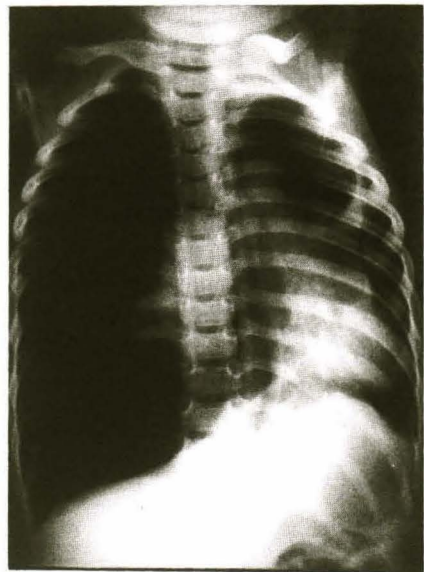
Chest radiograph reveals right tension pneumothorax. The mediastinum is shifted to the left side.
